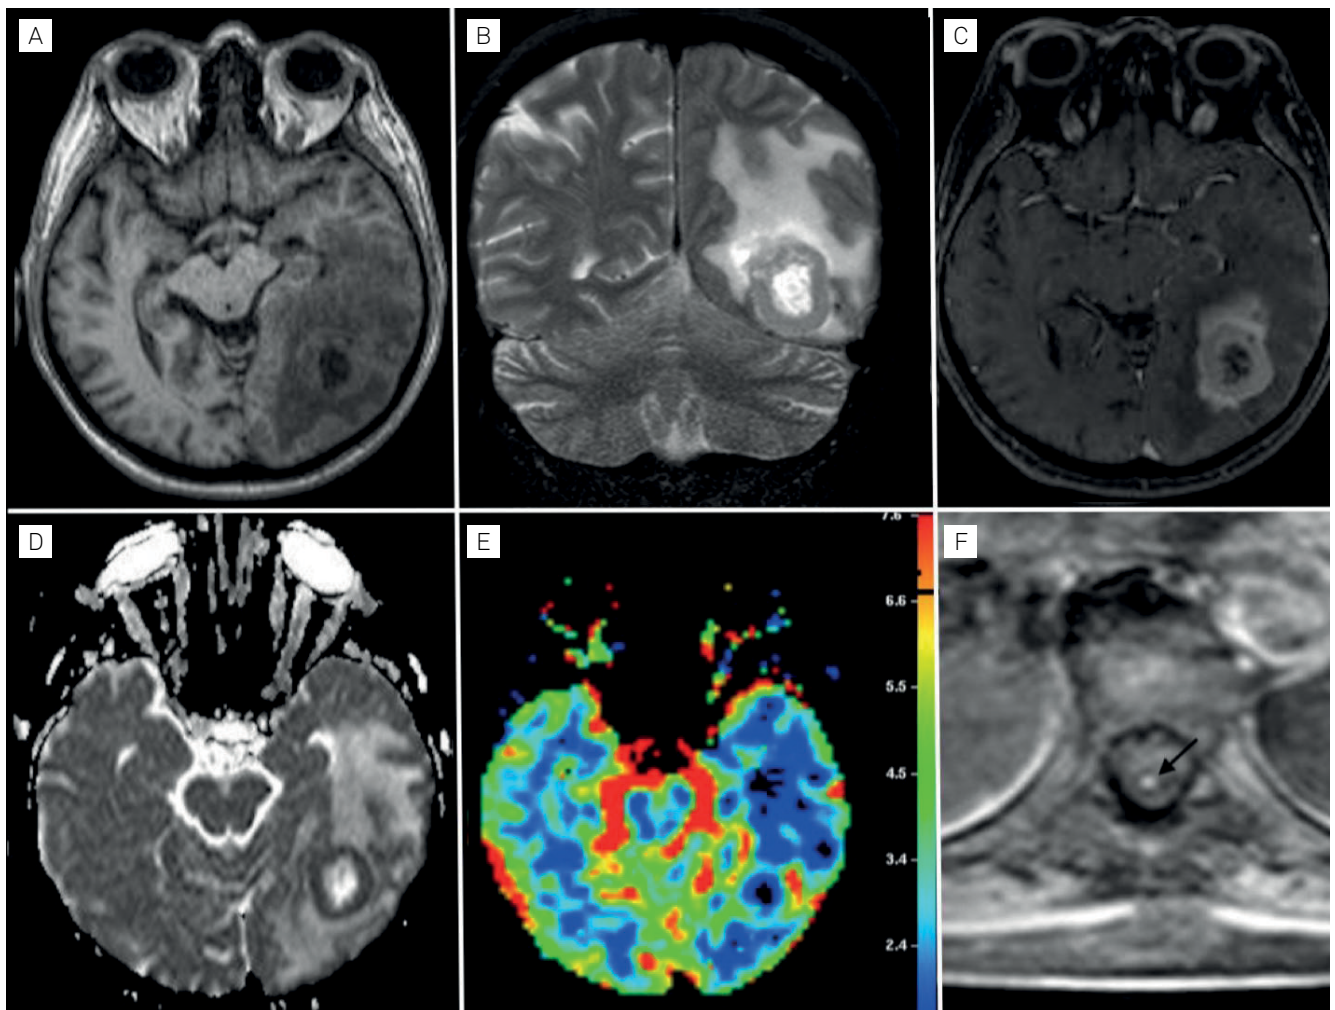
(A) Axial image T1-weighted without gadolinium showing an irregular lesion, with a central hypointense component (corresponding to the area of necrosis) associated with intense perilesional edema. (B) Coronal image T2-weighted demonstrating isointensity of the solid component and hypersignal of the internal component (necrosis), as well as hyperintensity in the peritumoral white matter. (C) Axial image T1-weighted after administration of gadolinium. Note the irregular and peripheral enhancement by the contrast medium. (D) Axial image of ADC map showing marked hypointensity at the periphery that coincided with the gadolinium-enhanced lesion area (non-necrotic area). The high cellularity restricted the diffusion of water molecules. (E) Perfusion map showing increased relative cerebral blood volume (rCBV) in the tumor. (F) Axial SPIR image after contrast administration. Note the gadolinium-enhanced area (arrow) in the spinal cord at T8 and T10 that was consistent with drop metastasis.
